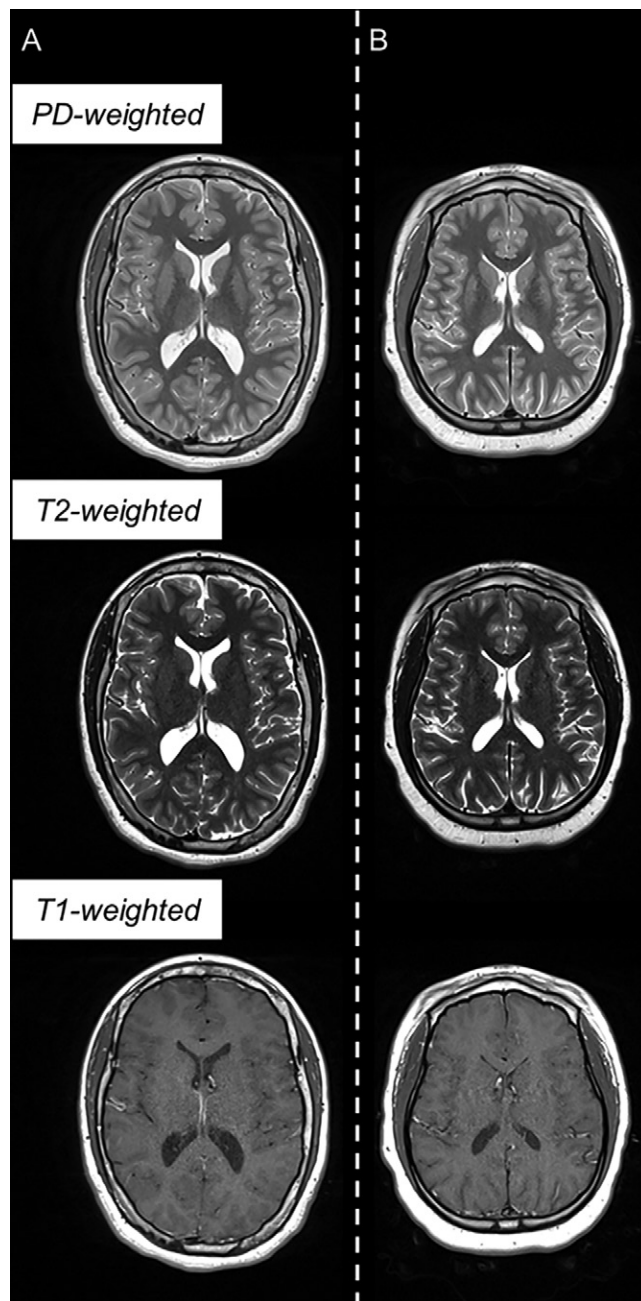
Example triple turbo spin-echo brain MRI scans in (A) neurotypically developing and (B) atypically developing extremely preterm–born adolescents. Proton density (PD)–weighted, T2-weighted, and T1-weighted images are provided. MRI scans in the atypically developing participant (full-scale intelligence quotient <85) demonstrated qualitatively smaller white and gray matter volumes and nearly indistinguishable tissue contrast compared with the neurotypically developing participant.
